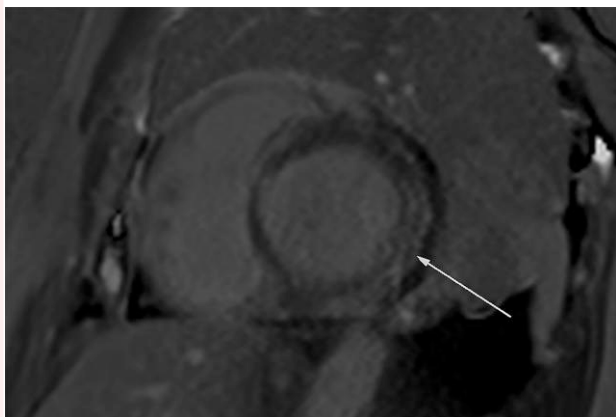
Cardiac MRI, hospital Day 5. LGE (Figure 3) and T_1 (Figure 4) imaging demonstrates sub-epicardial late gadolinium enhancement in the basal and mid-lateral left ventricular walls with native global T_1 of 1270 ± 67 ms.
